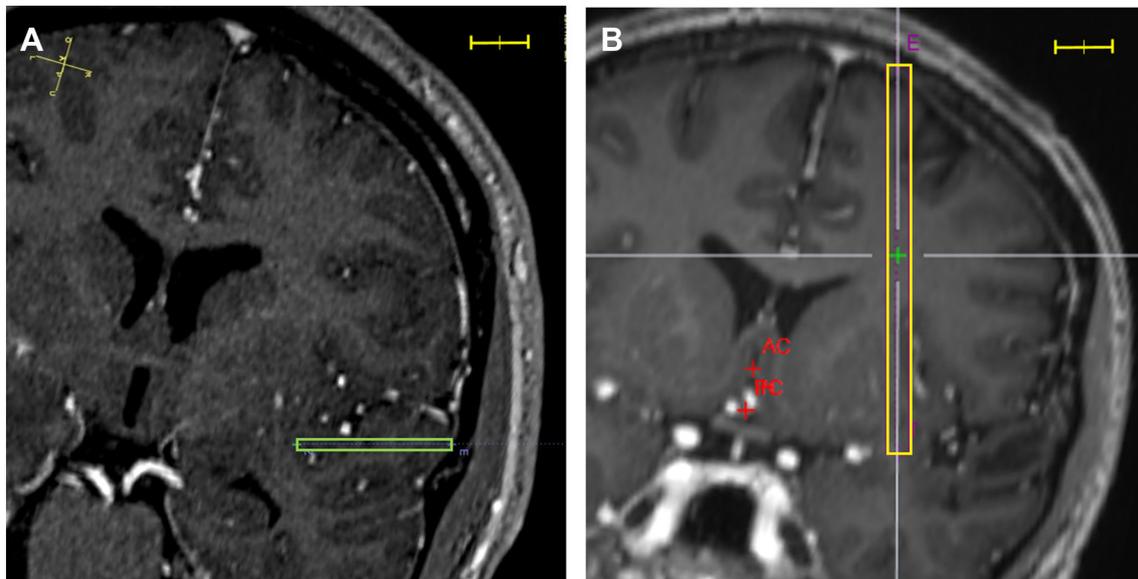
Strategies in planning of insular electrodes considering the different levels of precision. A) Referencing with the stereotactic frame (CT-frame) with a mean electrode deviation of < 2.5 mm allows a narrow trajectory through the frontotemporal (Sylvian) fissure containing the vessels of the mid cerebral artery. There is a safety zone of 2 mm around the trajectory, drawn in green. B) Alternative to A, a transcortical trajectory with wide safety zone was chosen in a radiation-free approach referencing with 3.0-T MRI and surface laser scan (3.0-T MRI-laser), considering a wider safety zone because of a mean electrode deviation of <3.5 mm. The safety zone (yellow lines) around the trajectory amounts therefore up to 4 mm. Scale bar 10 mm.
